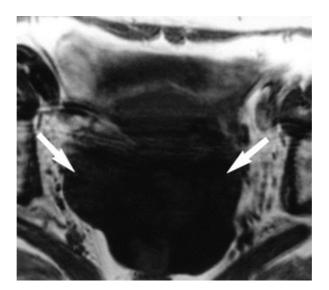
68-year-old woman with Brenner tumor. Axial T2-weighted (TR/TE, 2,000/80) (C), axial T1-weighted (600/15) (D), and axial contrastenhanced T1-weighted (E) MR images show enhancing ovarian solid mass (*arrows*). Low signal intensity on T2-weighted image is due to abundant fibrous stroma.
